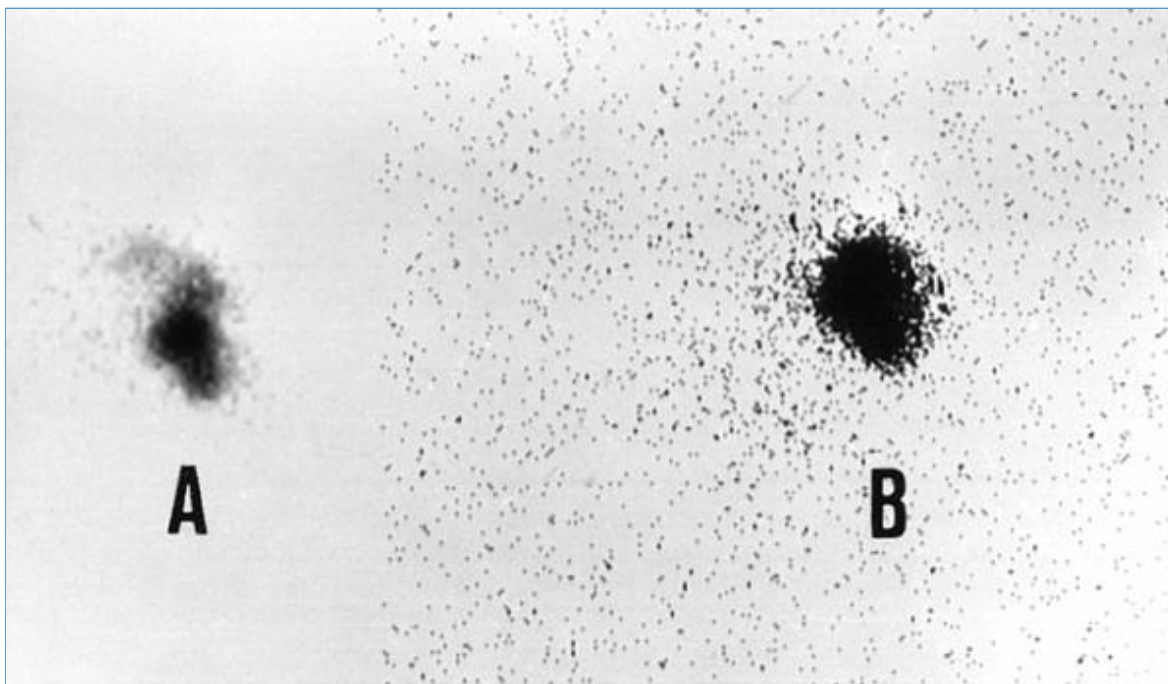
Rhinoscintigraphic pattern in total nasal obstruction. No pharyngeal activity appears in (A) early and (B) late imaging.
